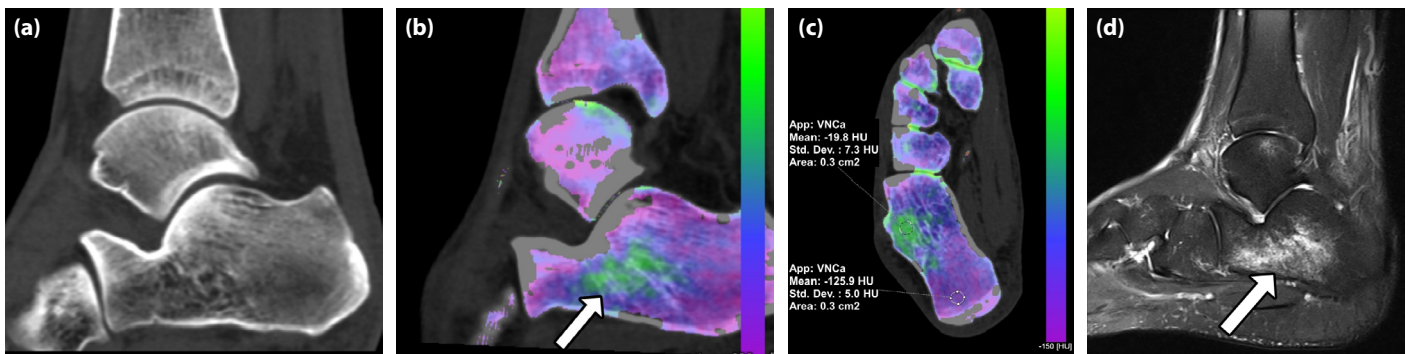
Images in a 34-year-old man with clinical suspicion of an ankle fracture 14 days after trauma: (a) Sagittal reformation of a conventional CT reconstruction, (b, c) DECT color-coded virtual noncalcium, and (d) Sagittal fat-saturated T2-weighted MRI scan image of the right ankle. Bone marrow edema in the calcaneus without fracture is visible both in the MRI and dual-energy CT (arrow in B and D). A significant difference in CT numbers between the areas with and without edema can be seen (circles in C) on the color-coded DECT image. Also, note the bone marrow edema of the talar dome (arrow in D) visible on MRI, which is not as pronounced in the color-coded DECT image.
